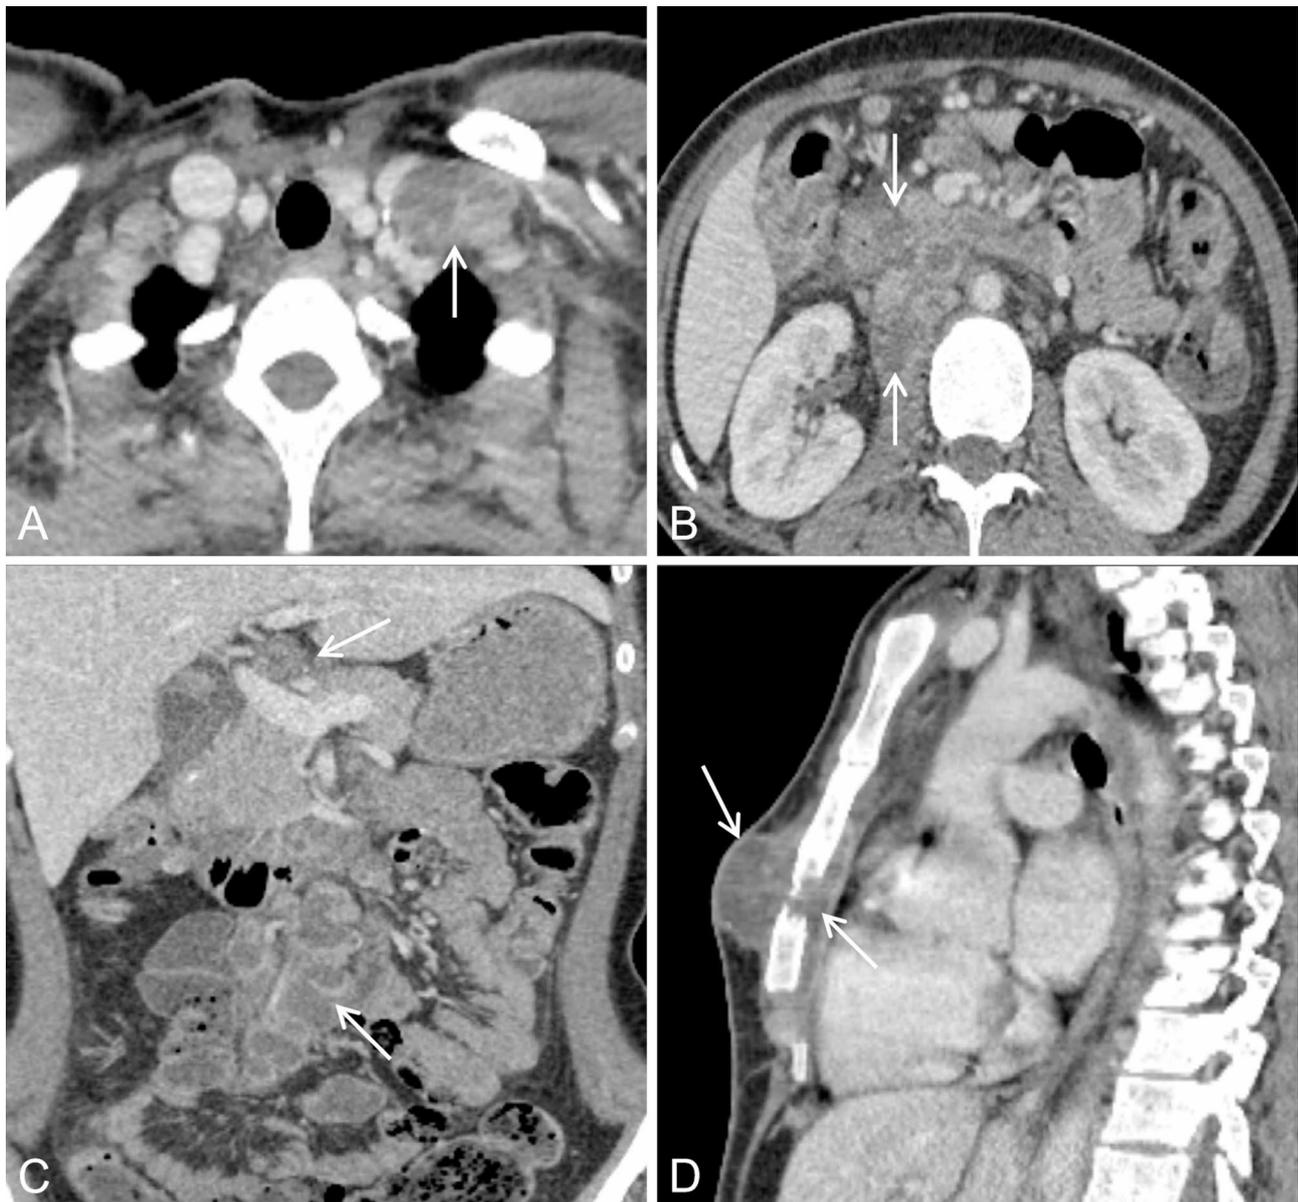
A patient with hematogenous disseminated ATBL suffered from upper abdominal pain and weight loss for 1 month. Axial contrast - enhanced CT demonstrated that the enlarged lymph nodes in the left neck presented with peripheral rim enhancement (white arrow) (A). Axial and sagittal contrast - enhanced CT images revealed multiple enlarged lymph nodes in the mesentery, para - aortic area, and hepatogastric ligament. These lymph nodes showed ring - shaped enhancement and were fused together (white arrow) (B, C). The sagittal contrast - enhanced CT image showed destruction of the sternum's bone, accompanied by the formation of a cold abscess in the chest wall (white arrow) (D)
